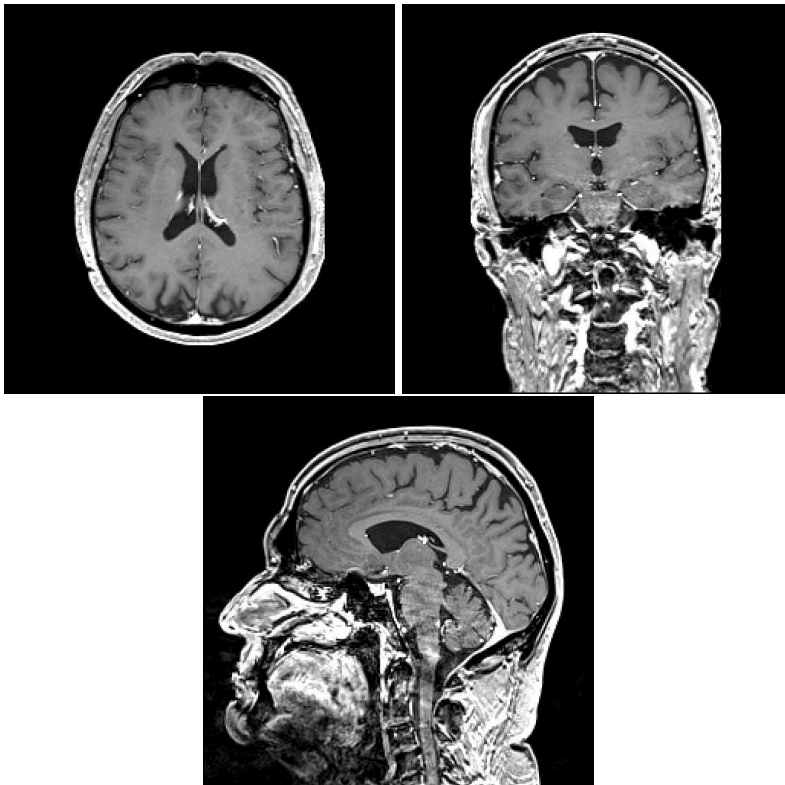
Axial, coronal and sagittal sections of the brain, obtained with a T_1 -weighted MRI sequence.
